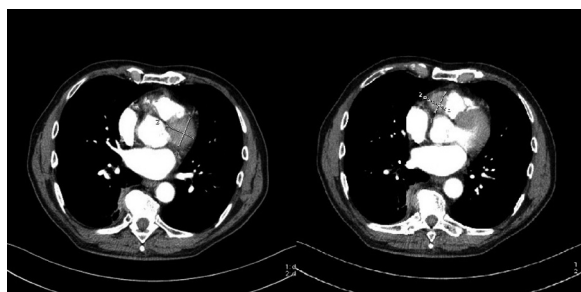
Thorax CT with contrast after 2 cycles of radionuclide therapy: intrapericardial tumours near pulmonary trunk and in the right ventricle
